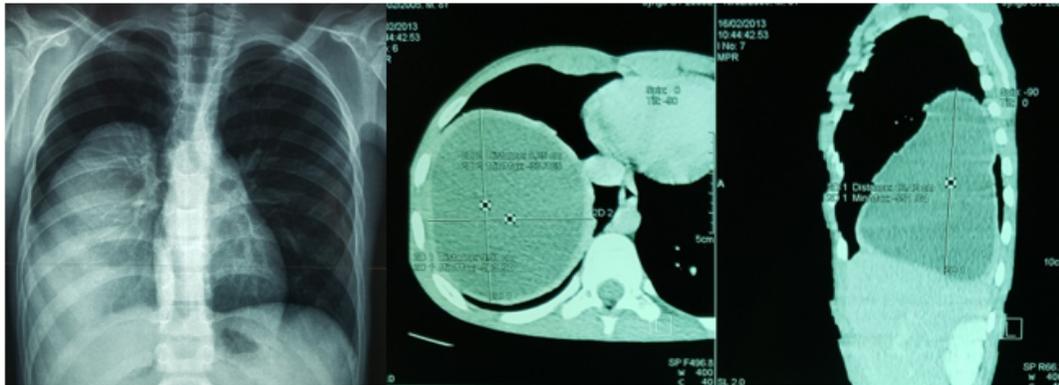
Preoperative chest x-ray with CT scan of hydatid cyst of right lung in 8 year old boy (13.5 x 10 cm).
